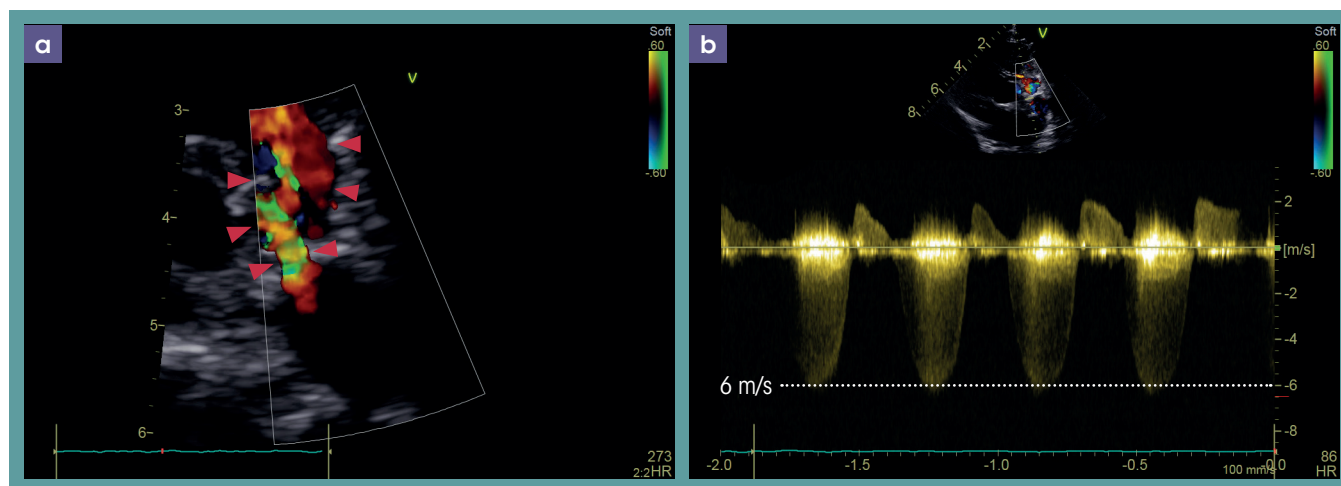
Doppler assessment of the hypoplastic, stenotic pulmonary artery. Colour flow Doppler mapping over the pulmonary valve (a) shows a tortuous, narrow route for blood flow and two apparent regions of stenosis (arrowheads). Continuous wave Doppler interrogation of flow across the hypoplastic region (b) identifies a maximum velocity of over 6 m/s, which is consistent with a very severe stenosis and a systolic right ventricular pressure of at least 169 mmHg (normal 25 mmHg).
